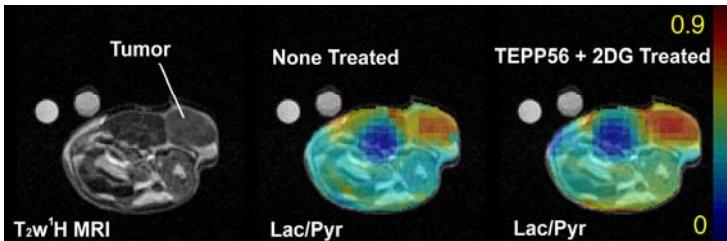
(Left) T2-weighted proton MRI of tumor slice, and Lac/Pyr metabolite maps before (middle) and 2hr after (right) TEPP46+2DG.
